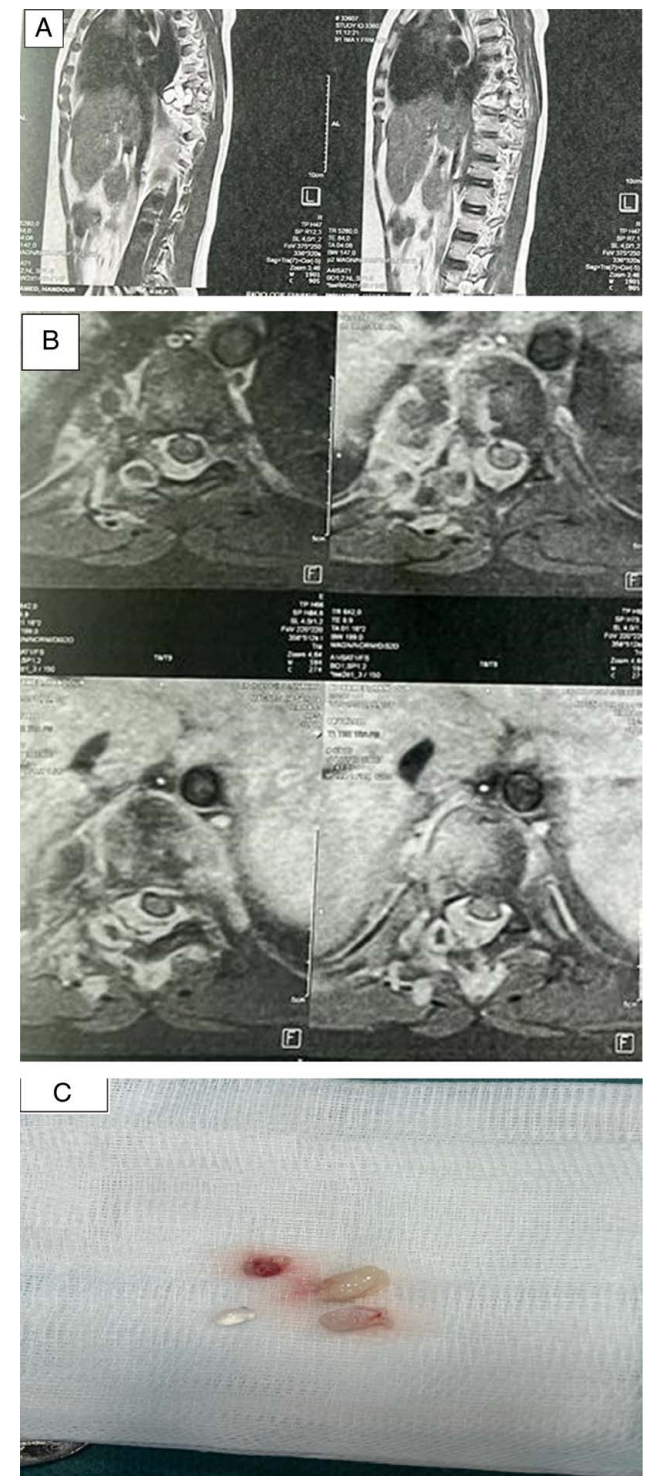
MRI. Sagittal image (A) and axial image (B) shows an aggressive hemangioma of the vertebral body D9 with involvement of the right vertebral arch and the posterior side of the vertebral body of D8. (C) Hydatid cyst found on the patient.
